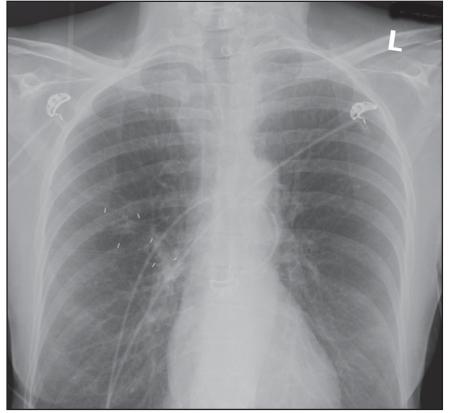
Anteroposterior (AP) radiograph of a patient with two right lung tumors, each with three fiducials.
